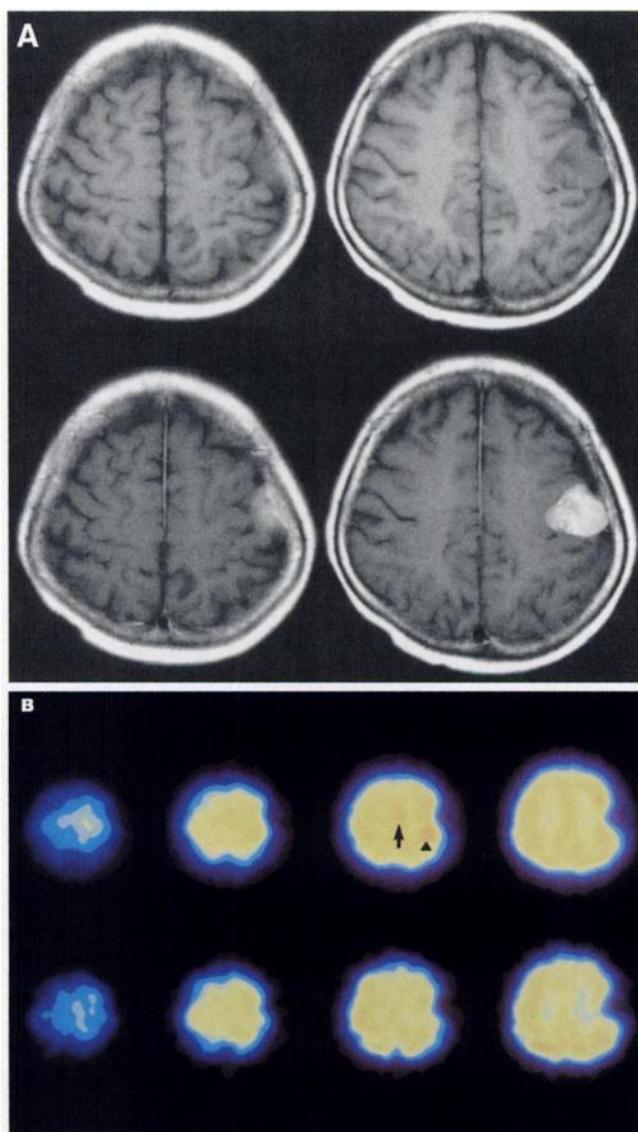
MR and SPECT images of 69-y-old woman with meningioma in left parietal lobe. (A) Upper 2 images are unenhanced MR images, and lower 2 are enhanced MR images. Lower images show abnormal enhancement in left parietal lobe. (B) Upper 4 images are activation SPECT, and lower 4 are resting SPECT. Motor task was fist making with right hand. Left SMHA (arrowhead) and SMA (arrow) are clearly visualized as hot spot foci on activation images. Left SMHA and SMA are not observed on resting images. Regional percentage change was 27% for SMHA and 25% for SMA.
